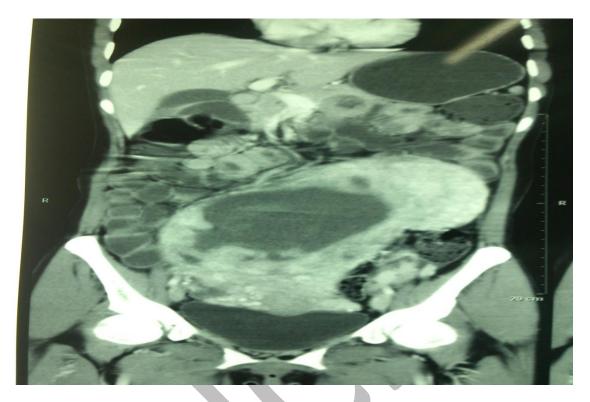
showing MRI imaging of uterine fibroid with cystic degeneration
